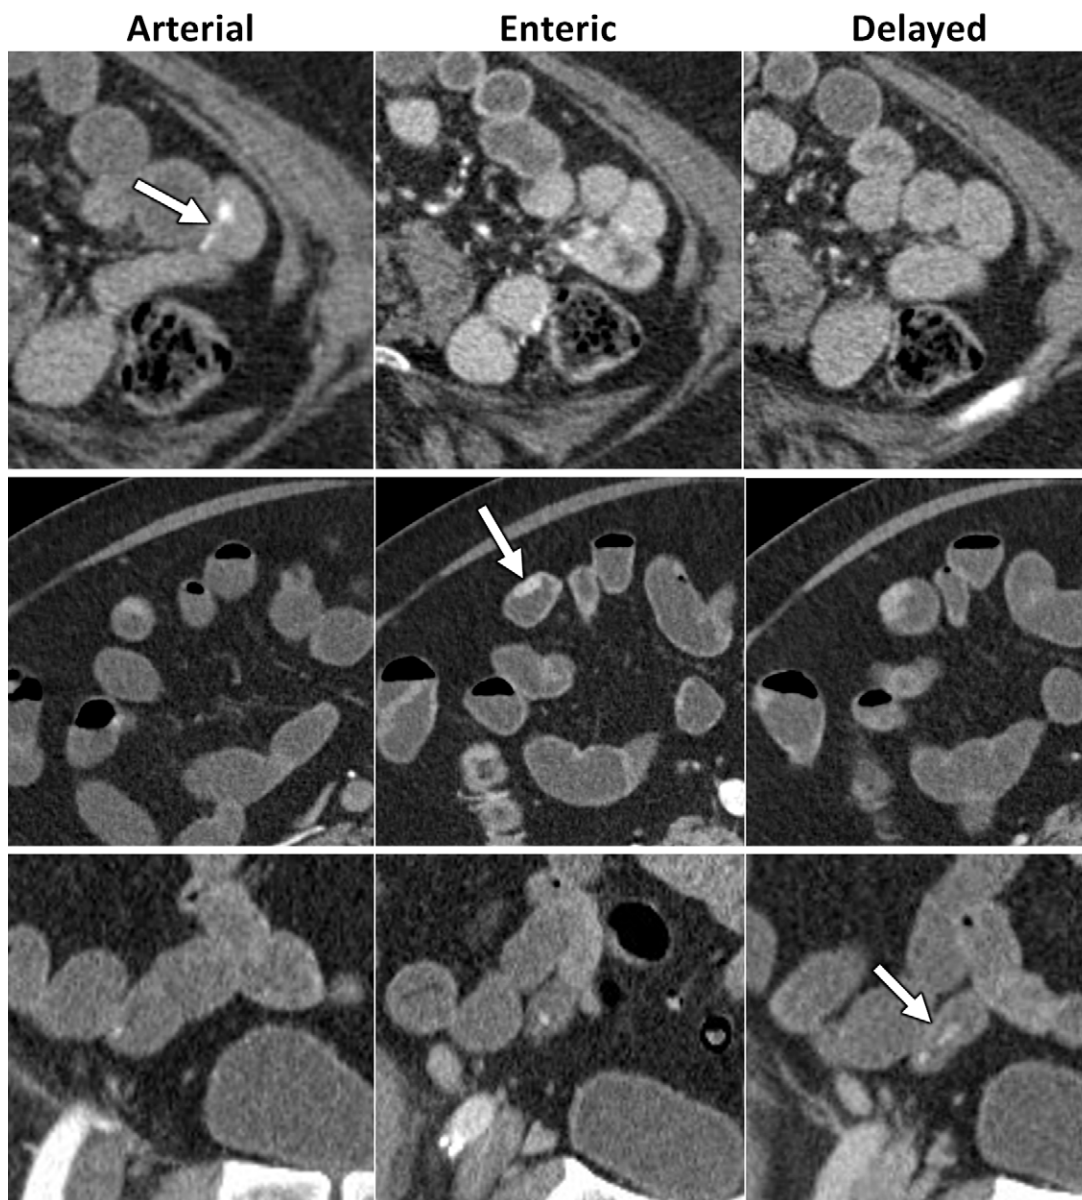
Multiphase CT enterography (CTE) images. Advantages of multiphase CTE for detection and characterization of gastrointestinal bleeding etiologies. The top row shows a Dieulafoy lesion (arrow), which is most conspicuous on the arterial phase. The middle row shows a small neuroendocrine tumor (arrow) most conspicuous on the enteric phase. The bottom row shows a slowly bleeding angioectasia (arrow) most conspicuous on the delayed phase. Reproduced with permission from the American Roentgen Ray Society from Multiphase CT Enterography Evaluation of Small-Bowel Vascular Lesions, Huprich et al, *American Journal of Roentgenology*, volume 201, issue 1, 65–72 (49); © 2013 American Roentgen Ray Society.
